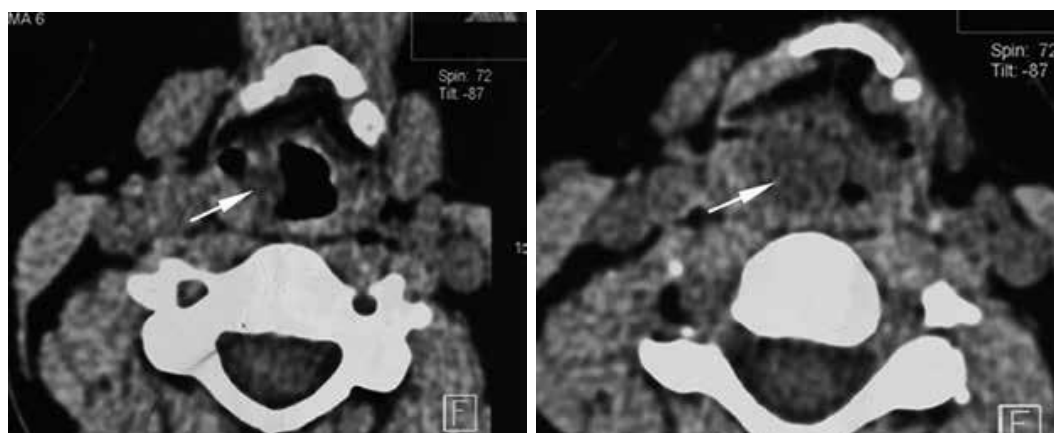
Computed tomography of the larynx, contrast-free examination, axial images at different levels of the larynx (A, B): in the right scooped fold, an additional formation of reduced density, obstructing the pear-shaped sinus (arrows).
